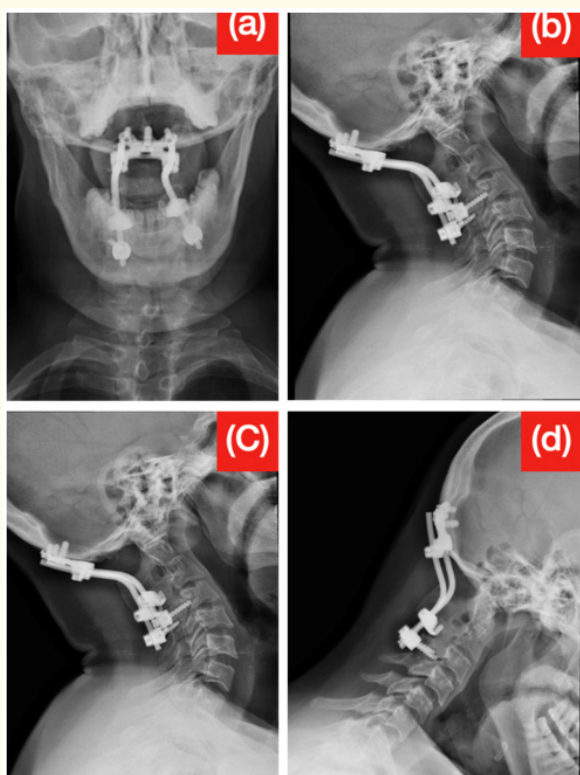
At 3-year-follow up, anteroposterior (a), lateral (b) and dynamic radiographs in hyperextension (c) and hyperflexion (d) of the cervical spine showing union of the graft at the site of the complete resection of the lesion and satisfactory alignment of the cervical spine with stable occipitocervical fixation. No evidence of residual or recurrent disease is detected.
